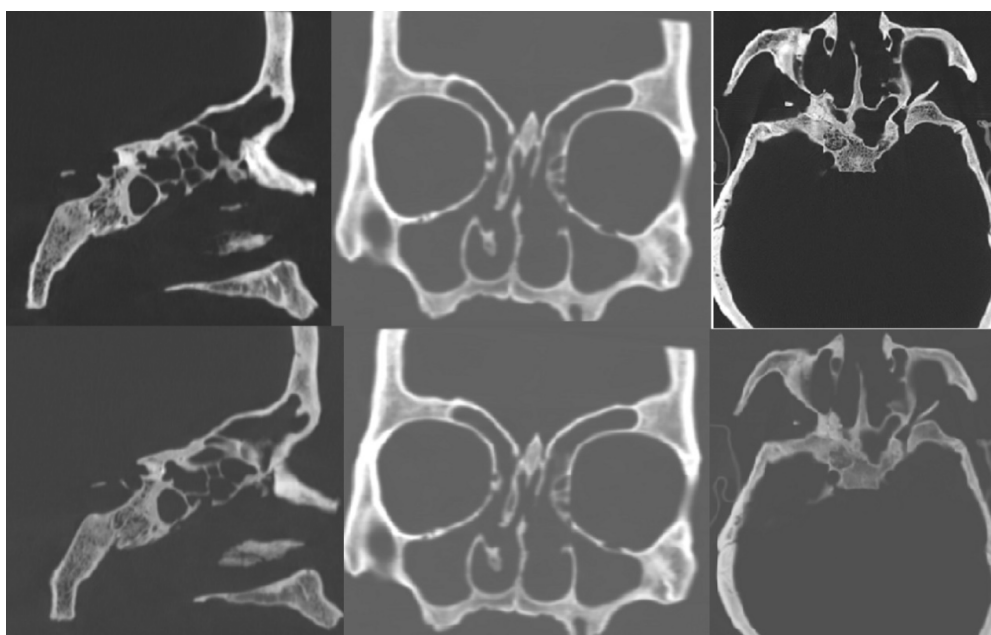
(upper row) High-resolution CT in axial, coronal and sagittal sections from right to left; (lower row) low-resolution CT in axial, coronal and sagittal sections from right to left
